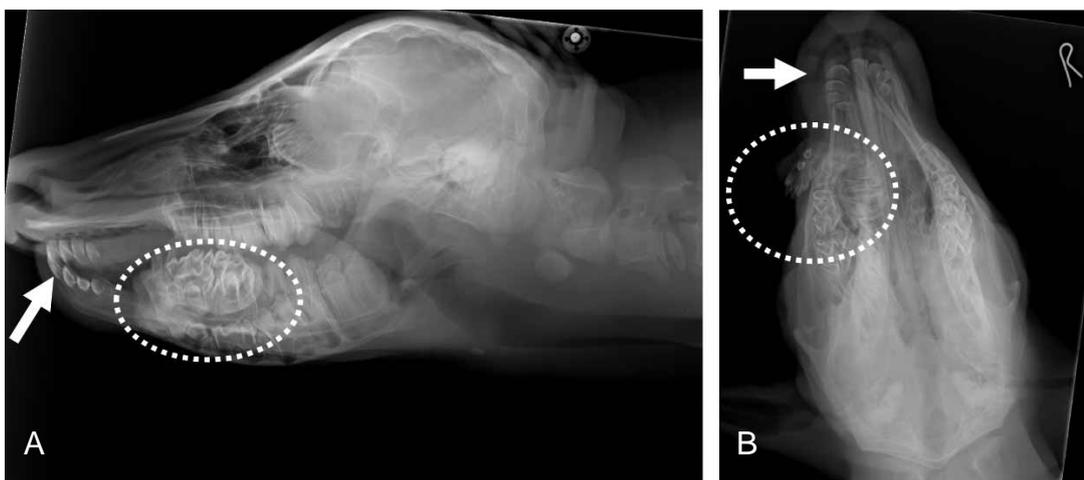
In the lateral (A) and ventrodorsal (B) radiographs of cranium, brachygnathia inferior (arrow) and accessory mandibular mass (dashed line).
